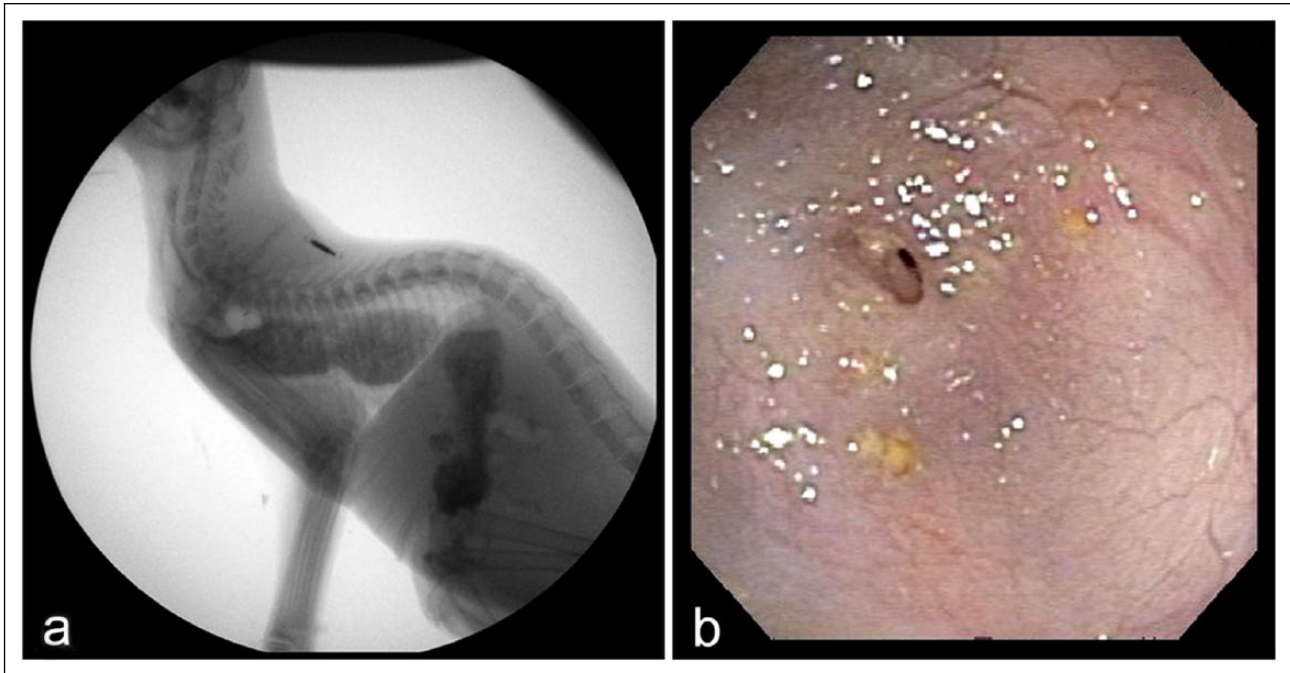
(a) Horizontal beam left lateral thoracic radiograph taken during fluoroscopy to examine swallowing. The contrast radiograph demonstrates liquid barium in the stomach and kibble mixed with barium retained in the non-motile esophagus. (b) Endoscopic view of the lower esophageal sphincter region demonstrating severe narrowing of the esophageal lumen diameter
